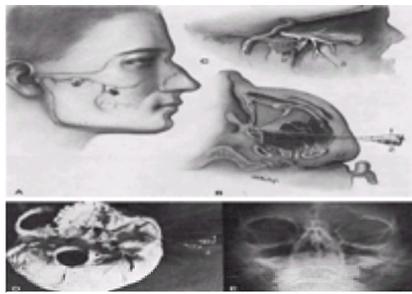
Technique of maxillary nerve block. A: Needles in place for the lateral and anterolateral routes. For the lateral route, a wheal is raised below the sigmoid notch of the zygomatic arch, and an 8-cm, 22-gauge needle threaded with a depth marker is introduced through it perpendicular to the skin and slowly advanced until the point strikes the lateral pterygoid plate at a depth of about 4 cm (B: 1). The marker is then set 1 cm from the skin, the needle is withdrawn until its point is subcutaneous, and it is readvanced in a slightly anterior and superior direction so that its point is 1 cm anterior and 1 cm superior to the point of bone contact made on the first insertion. The needle is carefully advanced in this direction until the marker is flush with the skin and the point of the needle is within the pterygopalatine fossa (B,C: 2). For local anesthesia, 2 mL of a local anesthetic may be injected slowly. If a neurolytic block is required, it is essential that the bevel of the needle be on or in the nerve. The nerve is located by eliciting paresthesia or by using a nerve stimulator. If the point of the needle is on the nerve, 1 mL of alcohol is injected, but, if the needle bevel is within the nerve, 0.4 mL is sufficient to destroy the nerve. D: Inferior view of the skull showing needle 1 with its bevel against the lateral pterygoid plate and needle 2 with its distal centimeter in the pterygopalatine fossa and its bevel in front of the foramen rotundum. E: Radiograph showing the needle in place and its bevel in front of the foramen rotundum. For the anterolateral route, a skin wheal is raised at the angle formed by the coronoid process of the mandible and the inferior border of the zygomatic arch, and an 8-cm, 22-gauge needle is introduced and advanced medially, superiorly, and slightly posteriorly (A,C). At a depth of 4 cm, the upper part of the posterior surface of the maxilla is contacted and the needle is advanced further with its bevel facing the bone to a depth of 4 to 5 cm, where contact with the bone is lost and paresthesia in the upper jaw is elicited. If difficulties are encountered, a nerve stimulator and radiographic control can be used. Once contact is made, the same volumes of local anesthetic or neurolytic agent, as mentioned for the lateral route, are injected.
